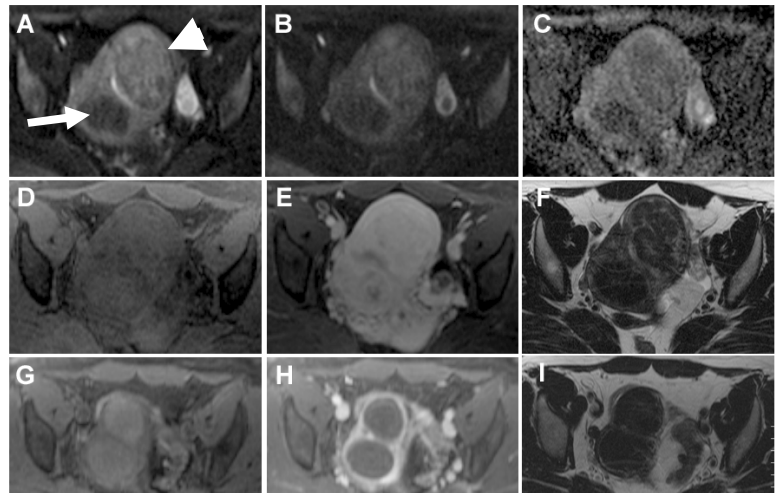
Pelvic MRI with DWI, b=500 (A), b=1000 (B) and ADC map (C). Pre (D) and post-contrast (E) and T2W images (F) before and after UAE (G,H,I). The larger anterior fibroid (arrowhead) demonstrates similar T1, T2 and post contrast enhancement characteristics but higher ADC pre UAE compared to the posterior fibroid (arrow). Following UAE, the anterior fibroid lacks enhancement and has diminished in size by 68% percent while the other posterior fibroid decreased only 26% despite lack of enhancement
